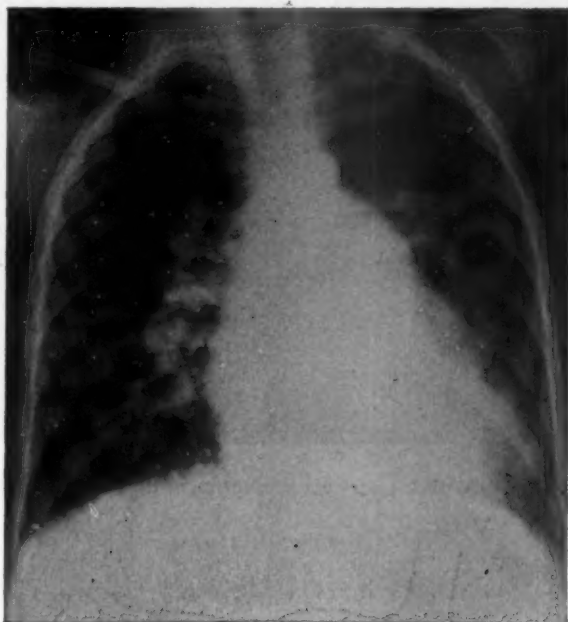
Radiography of Case 2.
